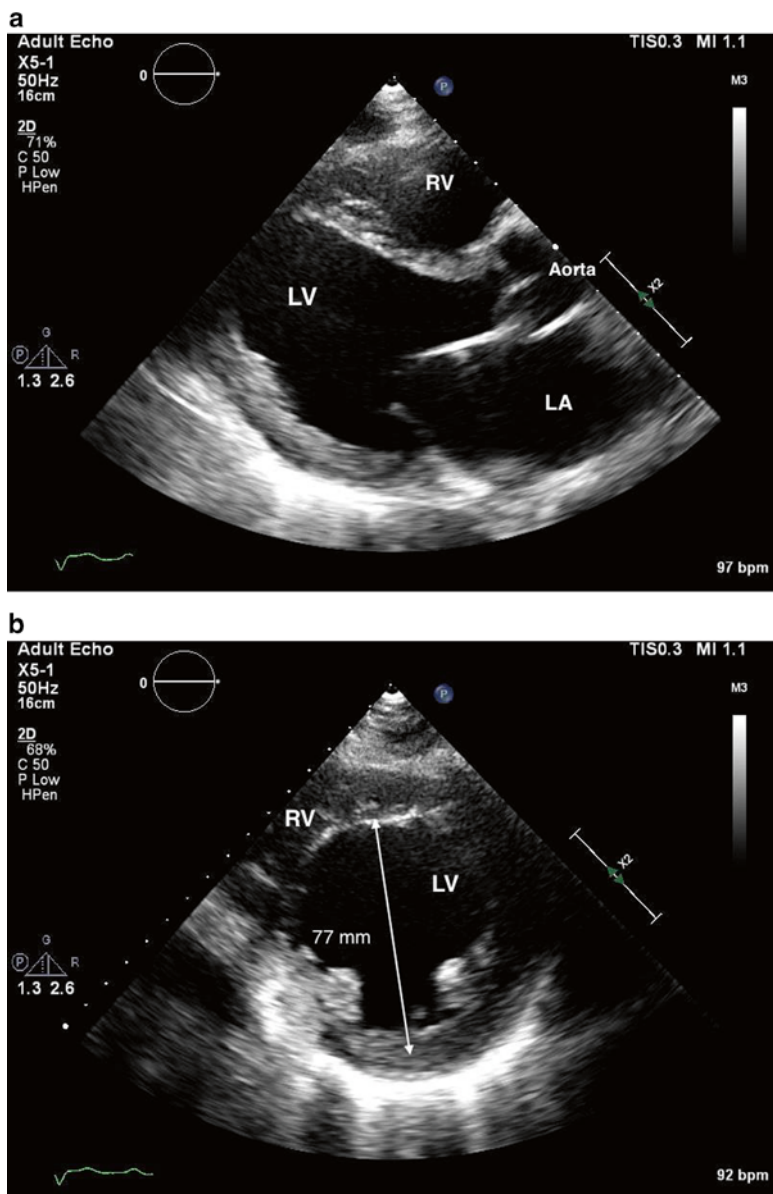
Parasternal long axis (a) and corresponding parasternal short axis (b) views. Severe left ventricular (LV) enlargement, with an end-diastolic dimension of 77 mm (upper limit of normal 57 mm). The right ventricle (RV), as seen in (a), is also enlarged
